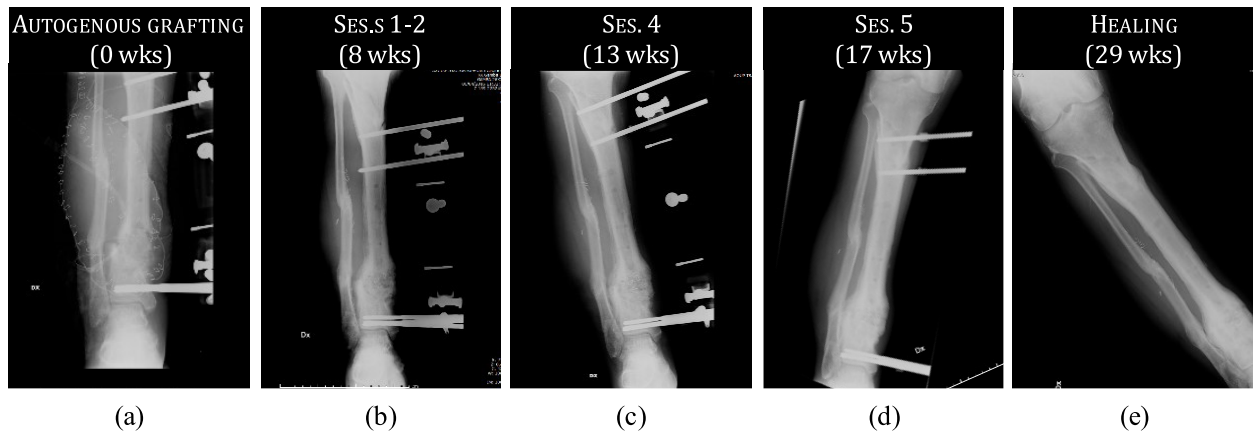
X-rays of the fractured leg from the autogenous grafting (0 wks) to the healing (29 wks). The formation of woven bone at wk 8 can be observed in (b). An initial hard callus constituted by trabecular bone is present, at least laterally, at wk 13 (c). At wk 17, a much more organized and tough structure was developing with the trabecular bone partially remodelled in compact bone (d). At 29 wk, the fracture appeared to be healed (e), though the bone remodelling will take many further months to restore the original structure and biomechanical properties of the bone.
